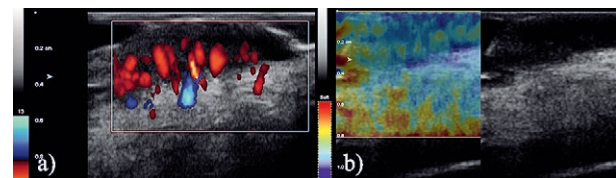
Cutaneous melanoma localized on the left lumbar region with multiple vascular pedicles on Doppler US (a) and stiff appearance on SE (b) in a 57 year old male. Breslow index 3.7 mm, thickness of the skin tumor measured by a 40 MHz frequency linear transducer was 3.8 mm.
